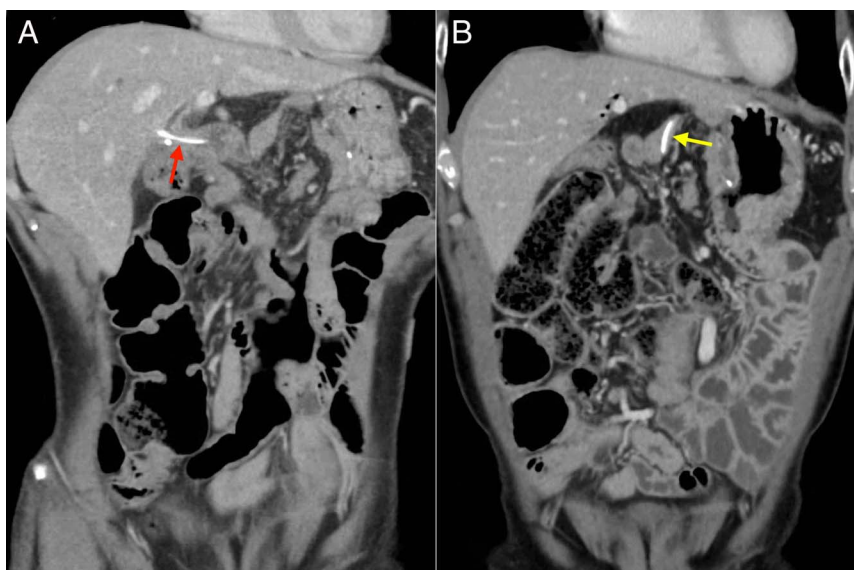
Contrast-enhanced computed tomography imaging reveals (A) a new biliary stent (red arrow) and (B) the pancreatic stent (yellow arrow) 2 months before is no longer present, which suggests migration into the choledochojejunostomy.
